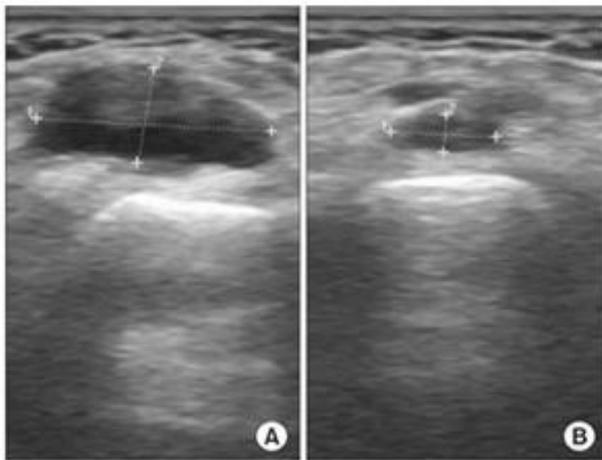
3 Sonographic Appearance of Ganglion
